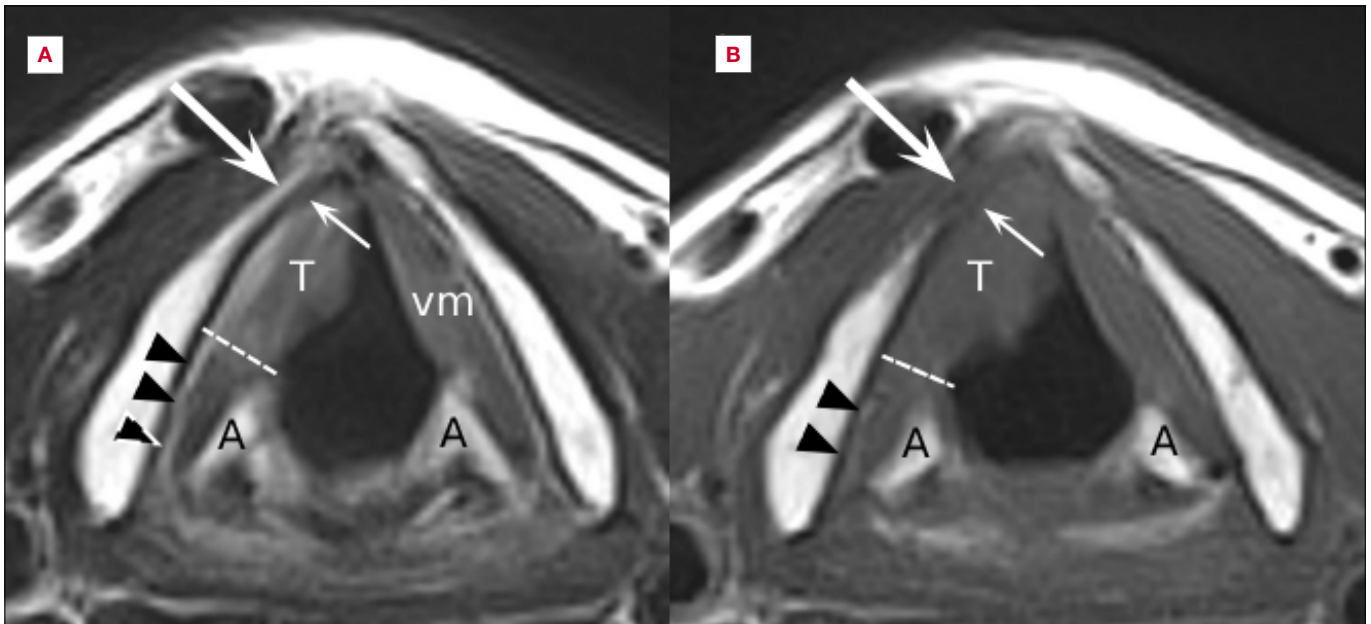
Axial T2-weighted (A) and unenhanced T1-weighted (B) images of squamous cell carcinoma of the right vocal cord (T) invading the most anterior part of the iPGS (effacement of fat signal, thin white arrow). In Figure 1B, a focal low signal in the anterior right thyroid lamina can be seen (thick white arrow), corresponding to high signal in Figure 1A (finding consistent with reactive chondritis). The lesion lies in front of the dashed line dividing the anterior and posterior compartments of the iPGS. Black arrowheads, posterior paraglottic fat. A: arytenoids; vm: vocal muscle.
